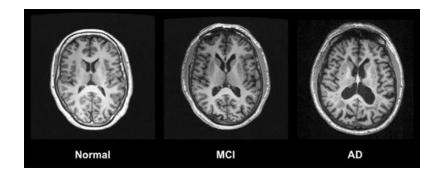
Shows MRI scan images of different stages of AD [9]
